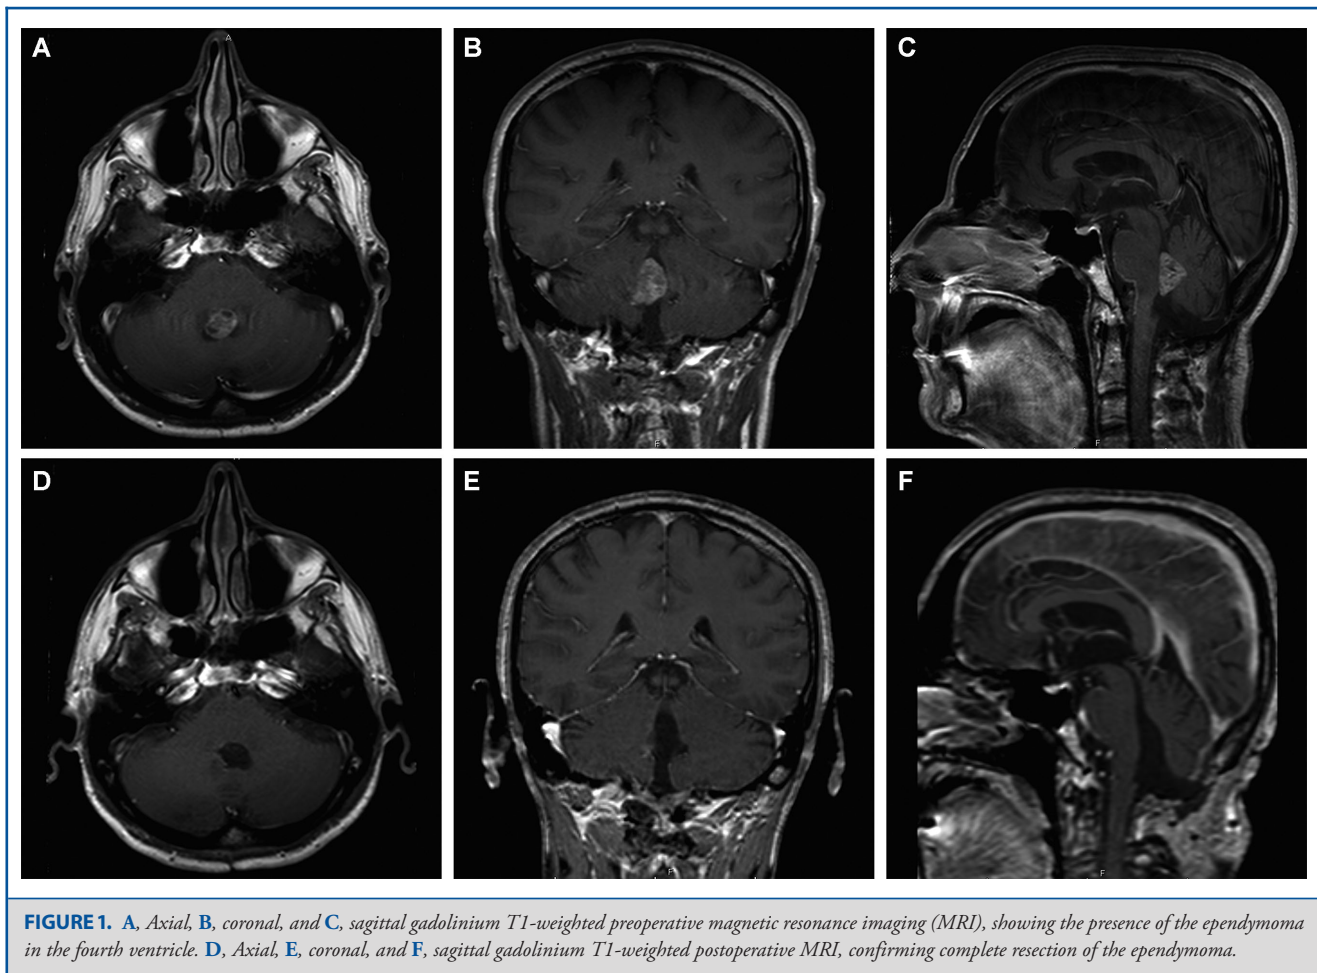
A, Axial, B, coronal, and C, sagittal gadolinium T1-weighted preoperative magnetic resonance imaging (MRI), showing the presence of the ependymoma in the fourth ventricle. D, Axial, E, coronal, and F, sagittal gadolinium T1-weighted postoperative MRI, confirming complete resection of the ependymoma.
